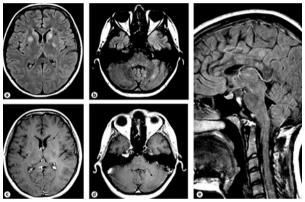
Brain magnetic resonance image (MRI) showing multiple bilateral round lesions with hyperintensity in fluid-attenuated inversion recovery (FLAIR) (a, c) and punctate contrast enhancement affecting the basal ganglia and the cerebellum on axial views (b, d) and typical "snowball" lesions in the central fibers of the corpus callosum on sagittal view (e). Lesions showed no abnormality on diffusion-weighted images (not shown).
